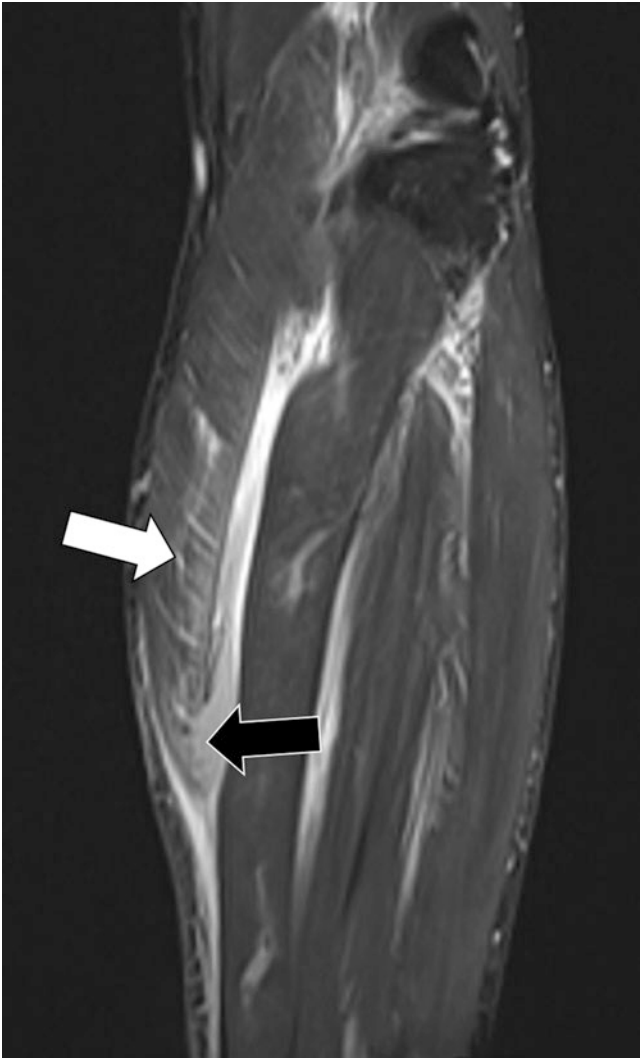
Coronal fat-saturated STIR MR image of the lower leg demonstrates extensive intramuscular and fascial edema at the distal gastrocnemius muscle (white arrow). Partial-thickness fiber disruption at the distal myotendinous junction (black arrow) is in keeping with grade 2 muscle injury
